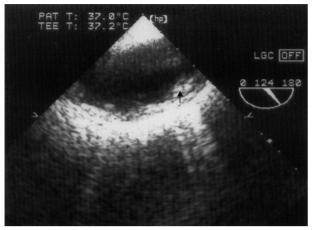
Transesophageal horizontal plane of descending thoracic aorta 3 cm below left subclavian artery showing marked irregularities of the intimal surface of the thoracic aorta with overlying shaggy echogenic material (arrow) from the intimal surface into the aortic lumen.
